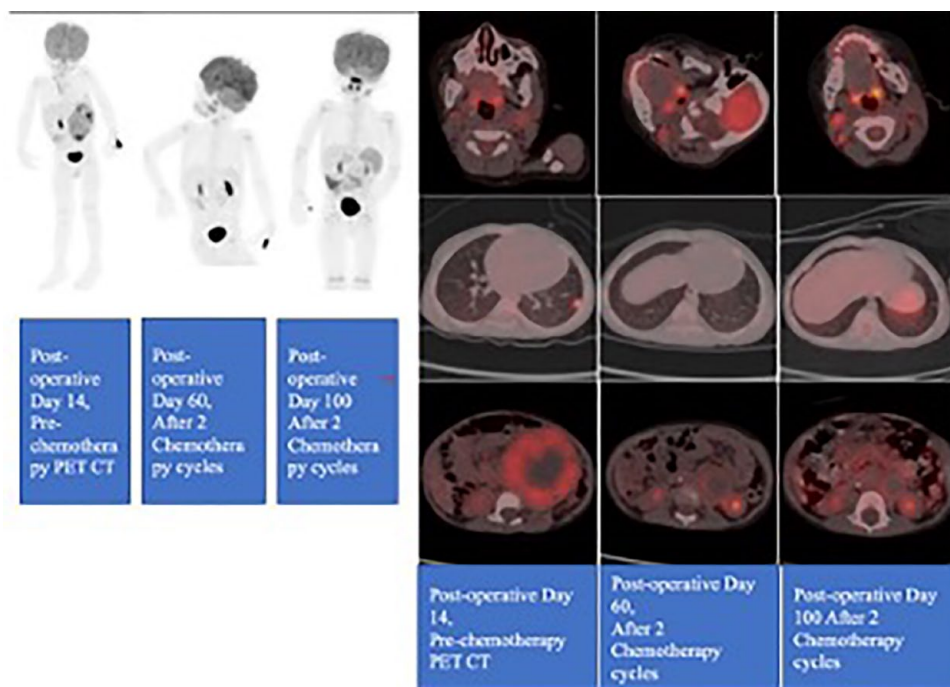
Comparison of the three PET-CT images with respect to the size of retroperitoneal mass.
